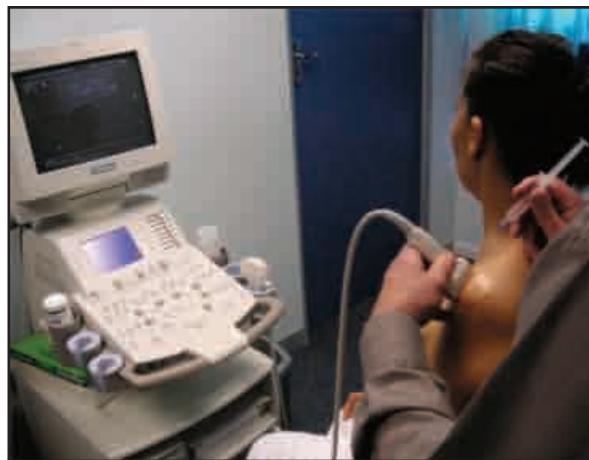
Ultrasound-guided acromioclavicular joint injection
